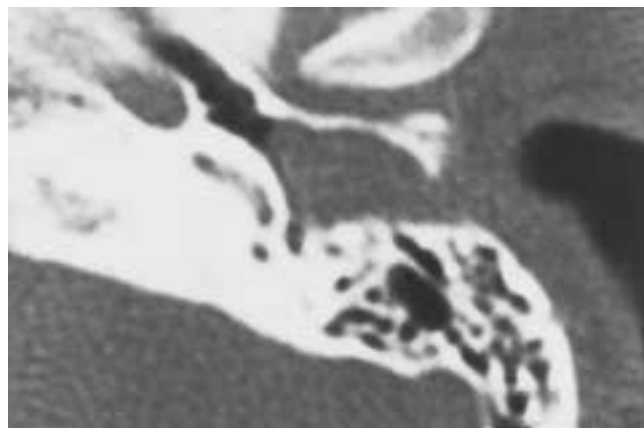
Keratosis obturans. Axial CT. A soft-tissue plug by itself is not a specific finding. There is mild diffuse thinning of the cortex of the EAC. The tympanic membrane is displaced medially, but the middle ear is normal.
